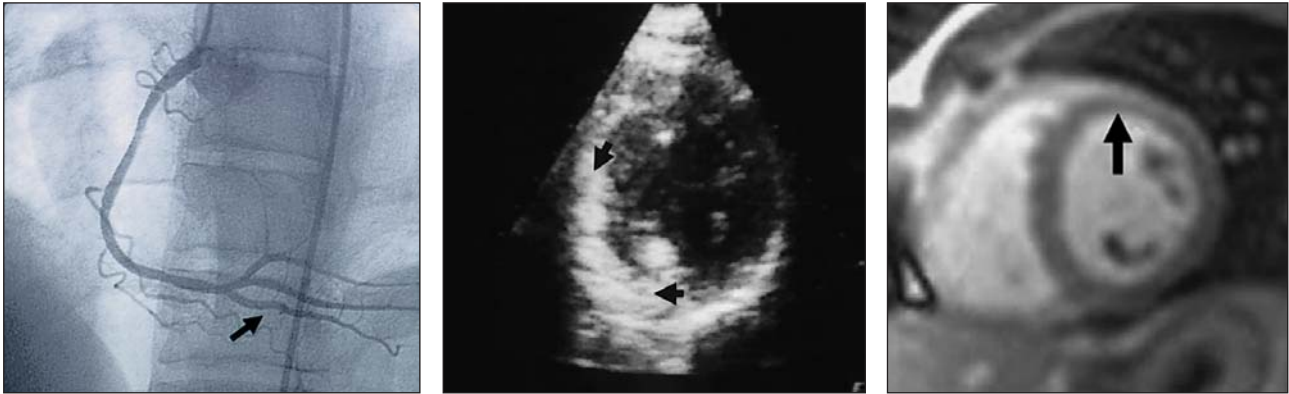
Patient with inferior infarction, right coronary artery initially occluded with blush grade 3 after intervention. Left: patent after stent placement with blush grade 3 (arrow). Center: normal perfusion in the infarct area (arrows) after injection of contrast into right coronary artery. Right: magnetic resonance imaging of normal perfusion (arrow).
